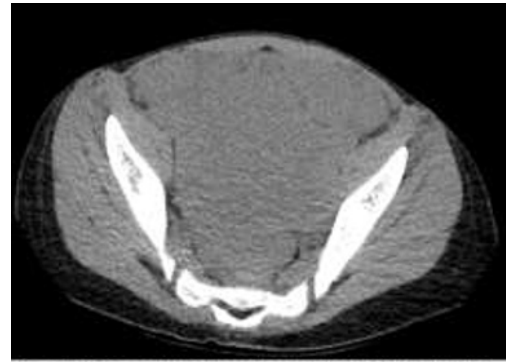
Initial non-contrast CT appearance suggests possible complex fluid or soft tissue mass in the abdomen and pelvis.
